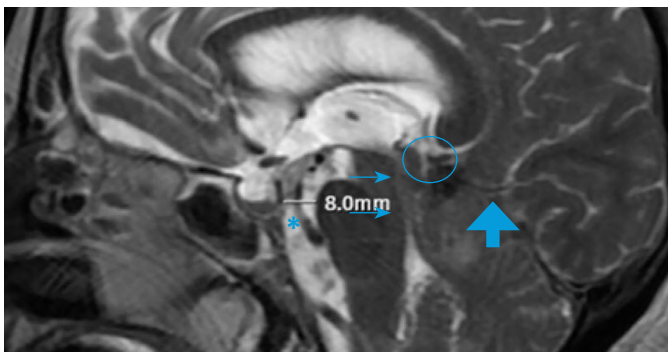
Magnetic resonance imaging from the second day of admission showed that the cerebellum and the superior and inferior colliculus were oedematous and subarachnoid spaces were completely closed (circle) by the mass effect of these structures. The ventral periaqueductal mid-brain was displaced anteriorly (short arrows). The tentorium was mildly elevated (thick arrow) and the prepontine distance was narrowed (asterisk).
